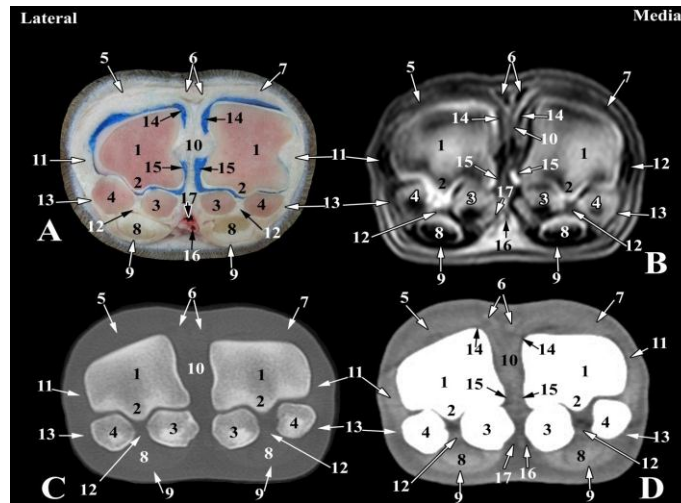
Transverse images of right fore fetlock joint of camel at the level of middle of proximal sesamoid bones (Level 2 as indicated in Fig. 1). A- Transverse anatomical section; B- Magnetic resonance image; C- Bone window computed tomography image; D- Soft tissue window computed tomography image: 1- Metacarpus; 2- Palmar sagittal ridge; 3- Axial sesamoid bones; 4- Abaxial sesamoid bones; 5- Lateral digital extensor tendon; 6- Lateral limb of common digital extensor tendon; 7- Medial limb of common digital extensor tendon; 8- Deep digital flexor tendon; 9- Superficial digital flexor tendon; 10- Axial collateral ligaments of fetlock joint; 11- Abaxial collateral ligaments of fetlock joint; 12- Palmar ligament of fetlock joint; 13- Collateral sesamoidean ligaments; 14- Dorsal synovial pouch of fetlock joint; 15- Palmar synovial pouch of fetlock joint; 16- Common palmar digital artery; 17- Common palmar digital vein.
